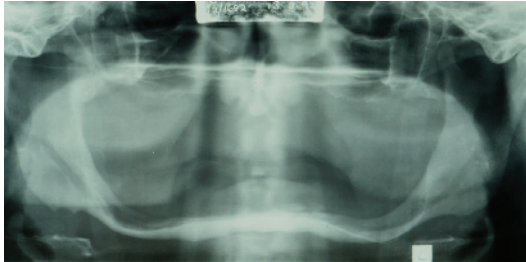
This orthopantomograph shows excessive resorption, particularly of the mandible.
